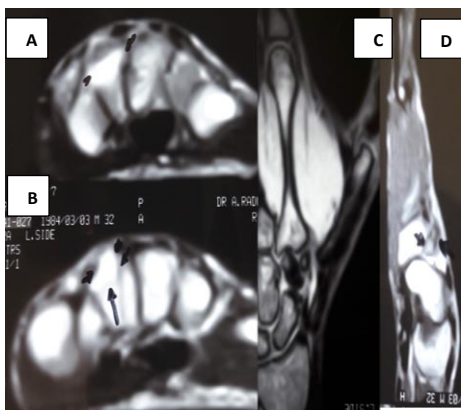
Magnetic resonance imaging (MRI) showing involvement of the trapezoid bone; A and B: Axial views; C: Coronal view; D: Sagittal view
